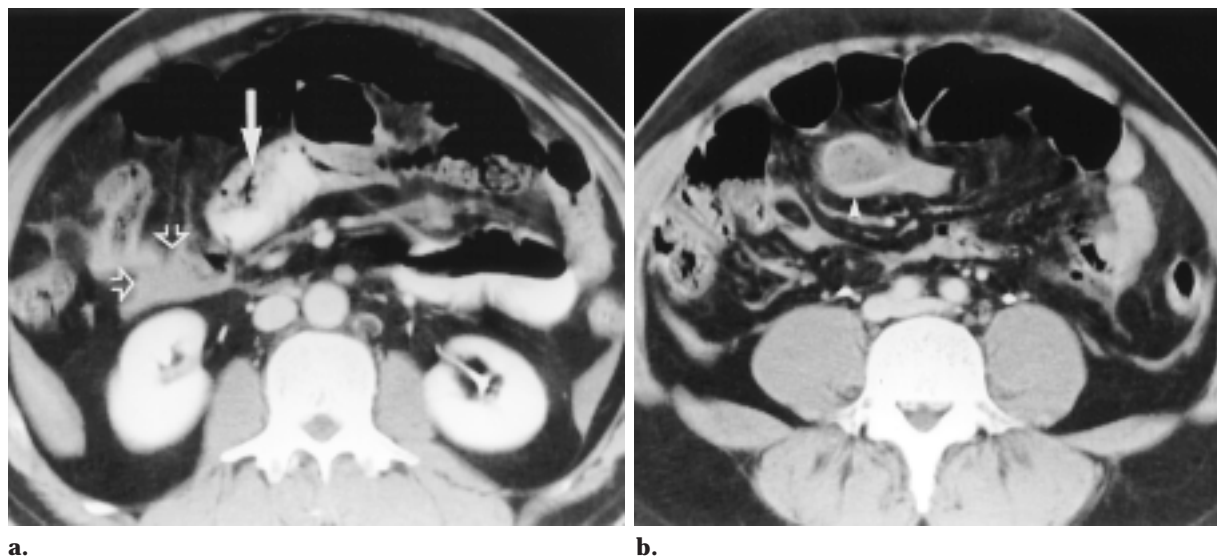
Proximal ileum perforation and mesenteric hematoma in a 41-year-old man. (a) Abdominal CT scan demonstrates intramural air in the ileum (solid arrow) and adjacent interloop free fluid (open arrows). (b) CT scan obtained at a lower level shows mucosal enhancement (arrowhead) of a more distal ileal segment.
